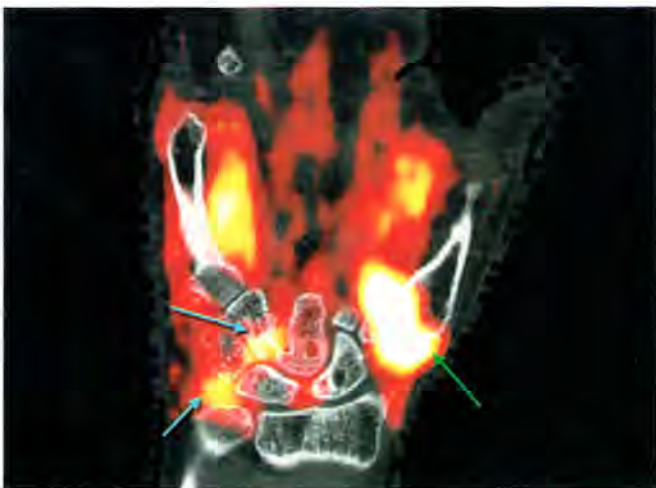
^{18}F -FDG high-resolution extremity PET/CT. Baseline high-resolution PET/CT.
